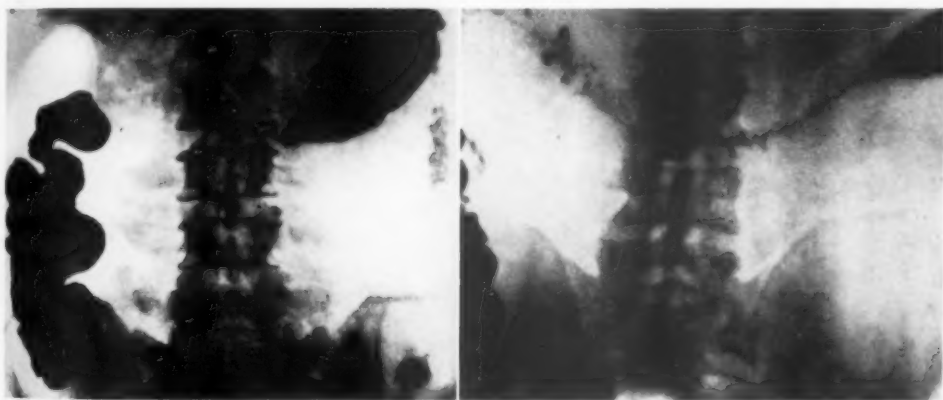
Normal mass peristalsis. Radiographs taken during the movement. By a stripping contraction, the contents of the transverse colon, spindle-shaped, are driven into the descending colon.
